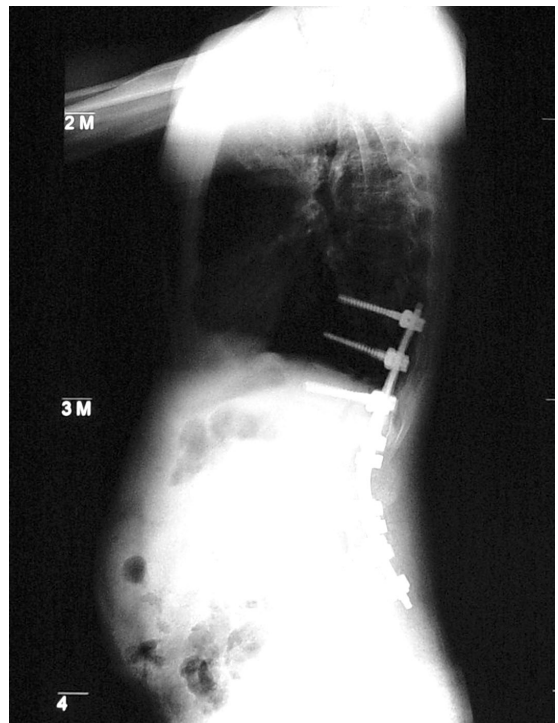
Postoperative lateral standing x-ray of the Case-1.
